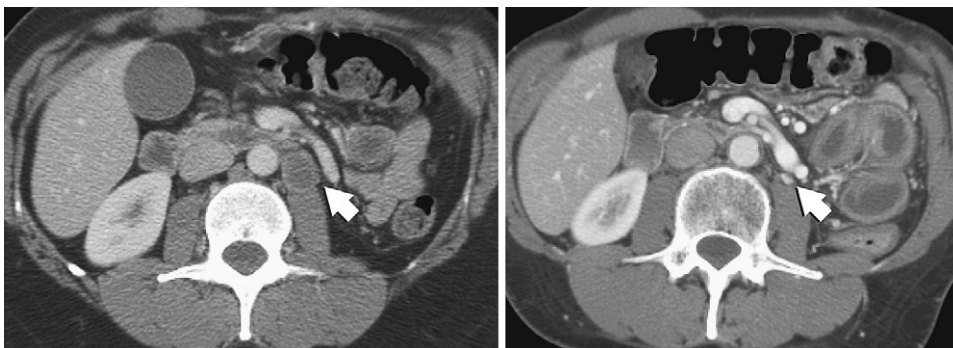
Abdominal computed tomography scans of 44-year-old woman with pancreatic gastrinoma initially treated with surgical resection, sandostatin, and adjuvant chemotherapy (cisplatin, carboplatin, irinotecan) with disease progression. Arrows identify para-aortic disease before (Left) and 3 months after (Right) a course of chemoradiotherapy.
